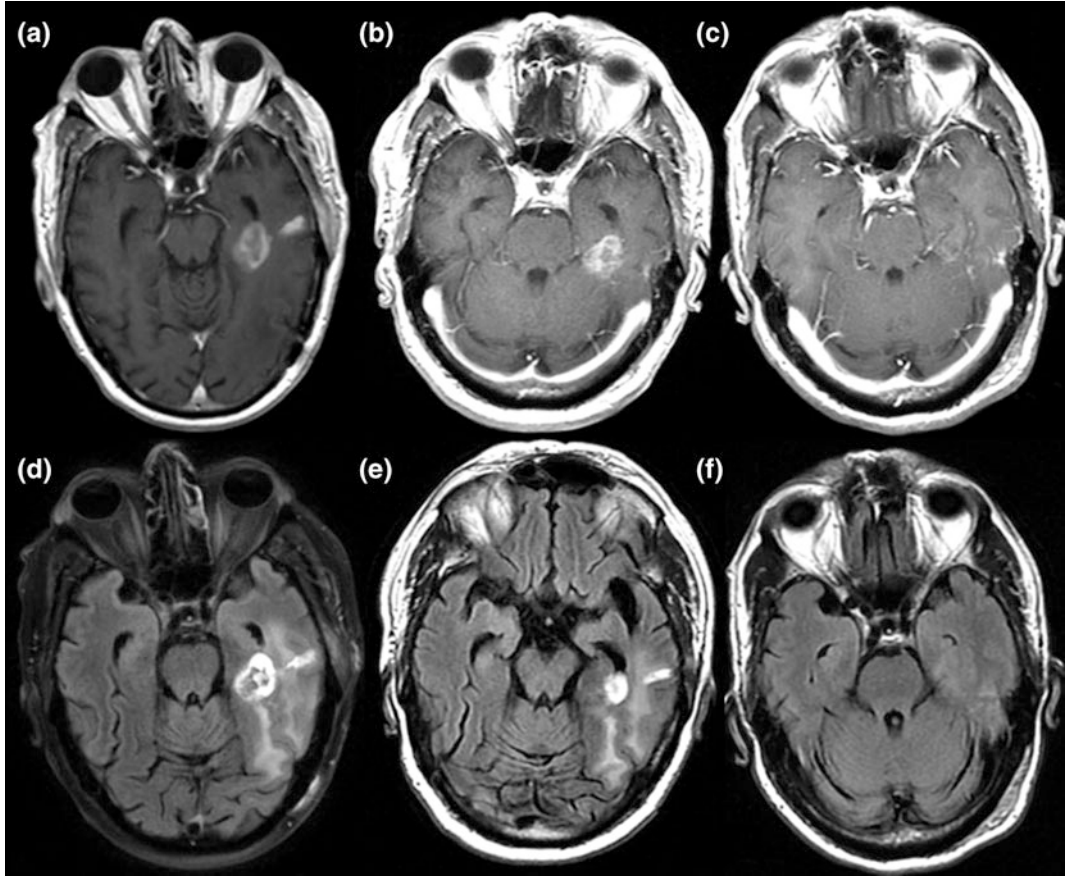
Postoperative imaging of LITT-treated lesion at 2, 6 weeks and 3 months after laser thermal coagulation. T1-weighted gadolinium sequences (a, c, e) show stable or marginally increased in size lesion over the first
